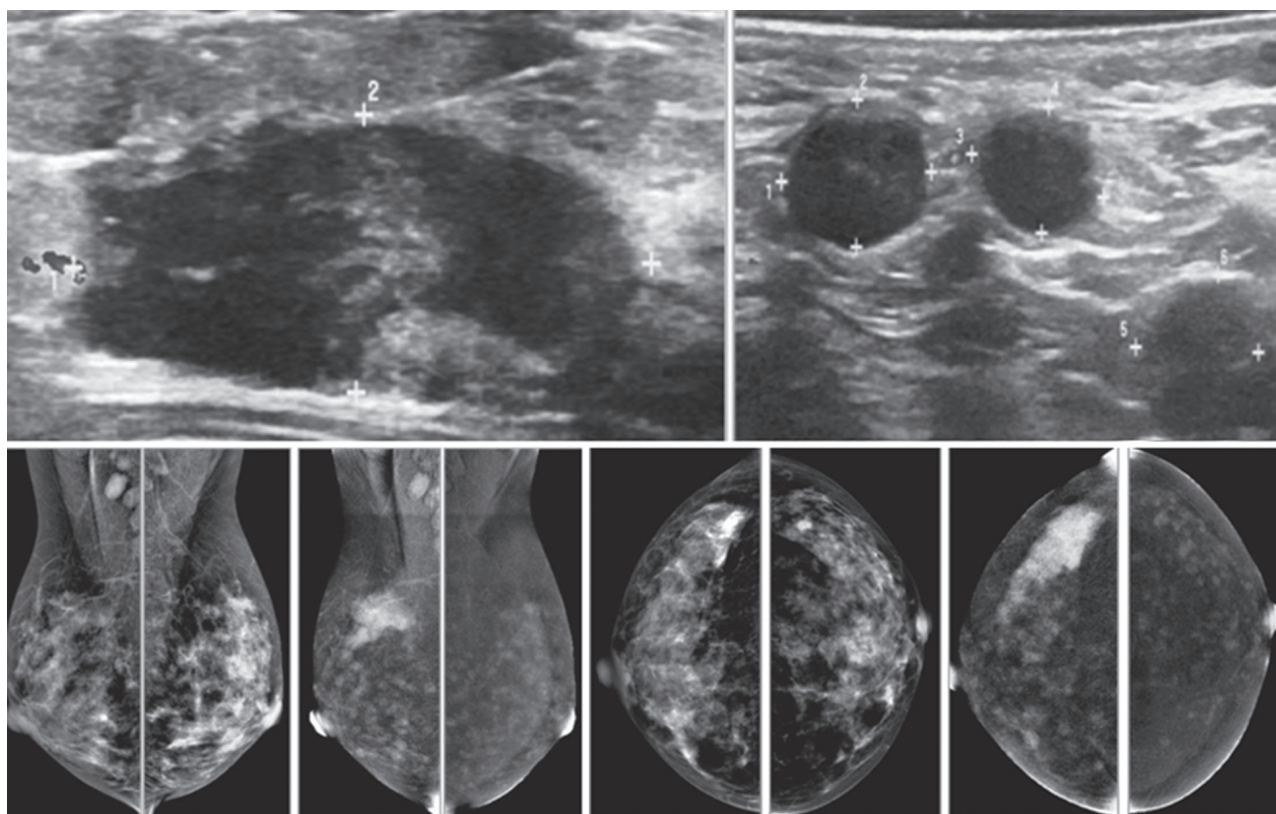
Female 48-years of age, ultrasound (US) shows a microlobulate, irregular shaped cystic mass, with internal solid component. Multiple enlarged axillaries denote a denopathy with round shape, almost echo-free, no fatty hila are seen. Mammography shows focal density in craniocaudal (CC) view, not well defined in mediolateral oblique (MLO) view. CESM shows intense enhancement of that complex lesion, with its size much increased. Numerous enhanced small foci are noted in both breasts. US guided core needle biopsy (CNB) reveals invasive ductal carcinomas and these are confirmed in surgery.
